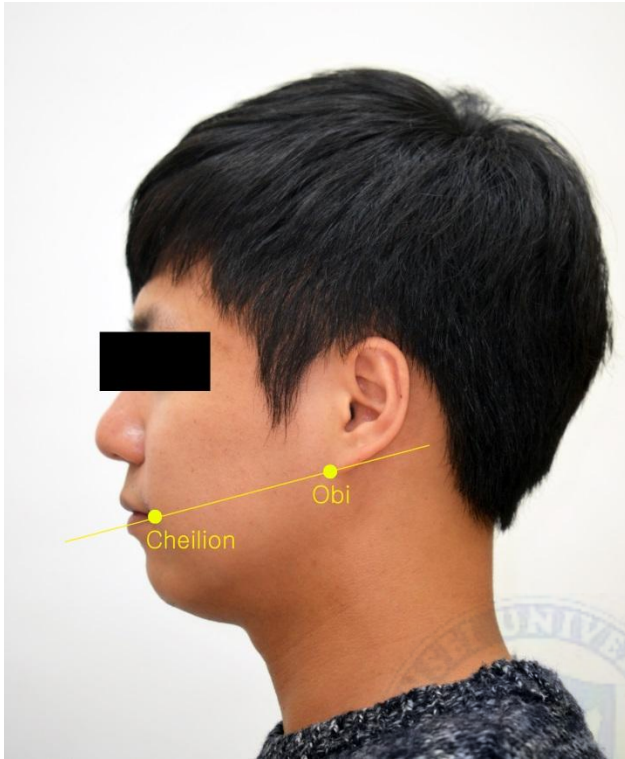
Horizontal reference of ultrasonography: Cheilion (a cephalometric point located at the corner of the mouth) - Obi (a cephalometric point of attachment of the ear lobe to the cheek)
